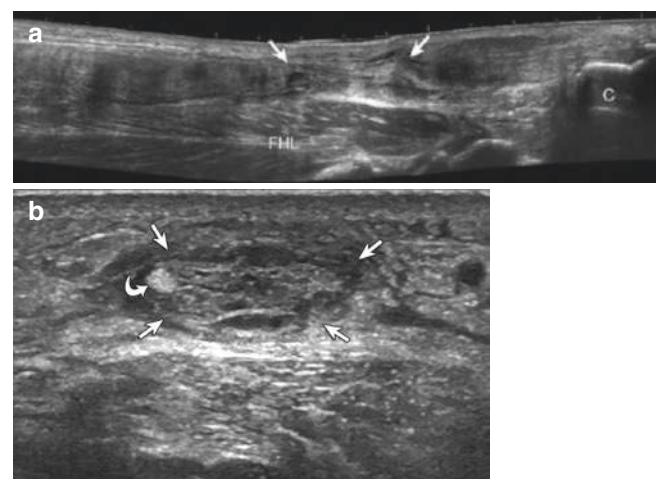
Achilles tendon: full-thickness tear. Ultrasound images (a) long axis and (b) short axis to the Achilles tendon show heterogeneous hypoechoic tendon disruption with tendon retraction (between arrows). Note intact plantaris tendon (curved arrow) at medial aspect (FHL, flexor hallucis longus; C, calcaneus)
